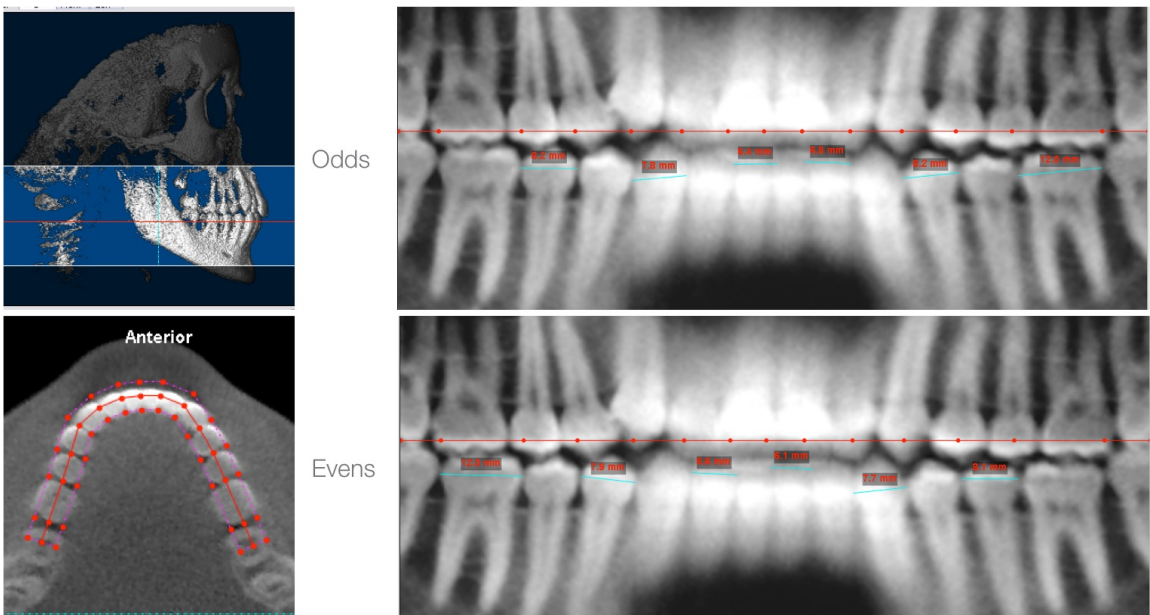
Method 3: CBCT Detailed Pano - Dolphin (Mandible).
